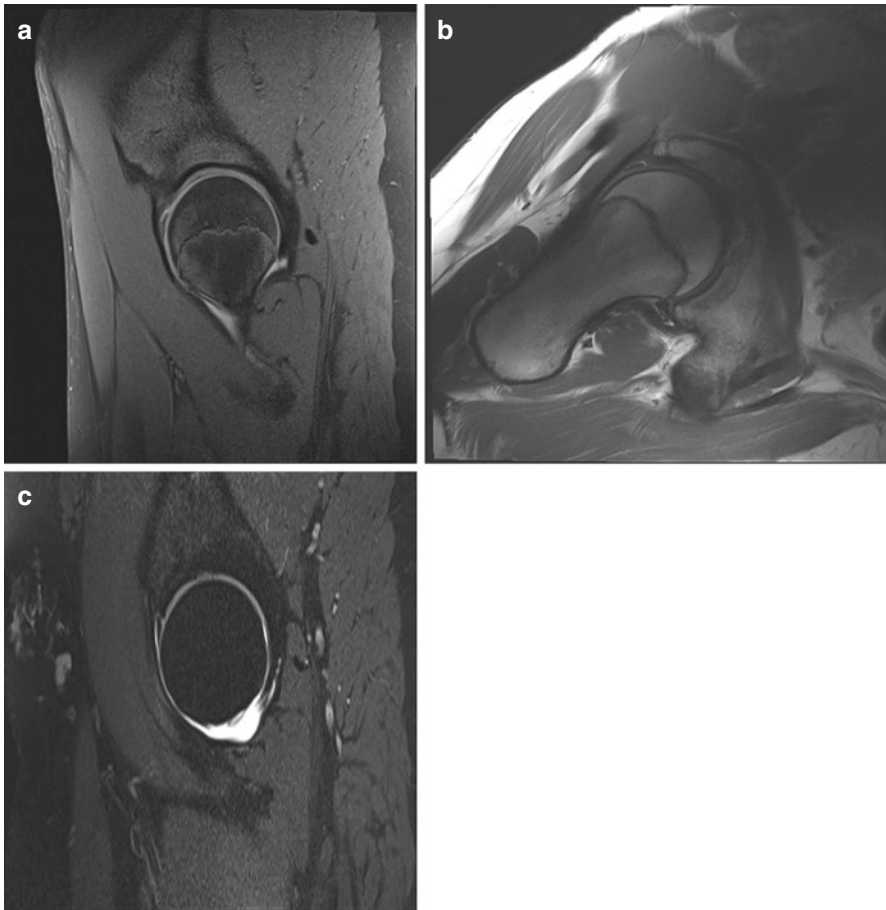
Anterior labral tear. (a) 3.0T MRI of the left hip. Sagittal oblique plane. Linear high signal at the anterior labrum is in keeping with a tear. (b) 3.0T MRI of the left hip. Axial oblique plane. Linear high signal at the anterior labrum is in keeping with a tear. (c) 1.5T MR arthrogram. Axial oblique plane of the left hip in a different patient demonstrating an anterior labral tear
